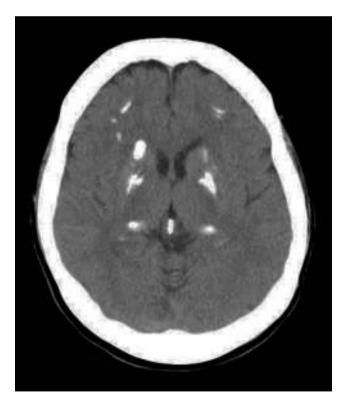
Axial CT: calcifications observed in bilateral frontal and periventricular basal ganglia.
